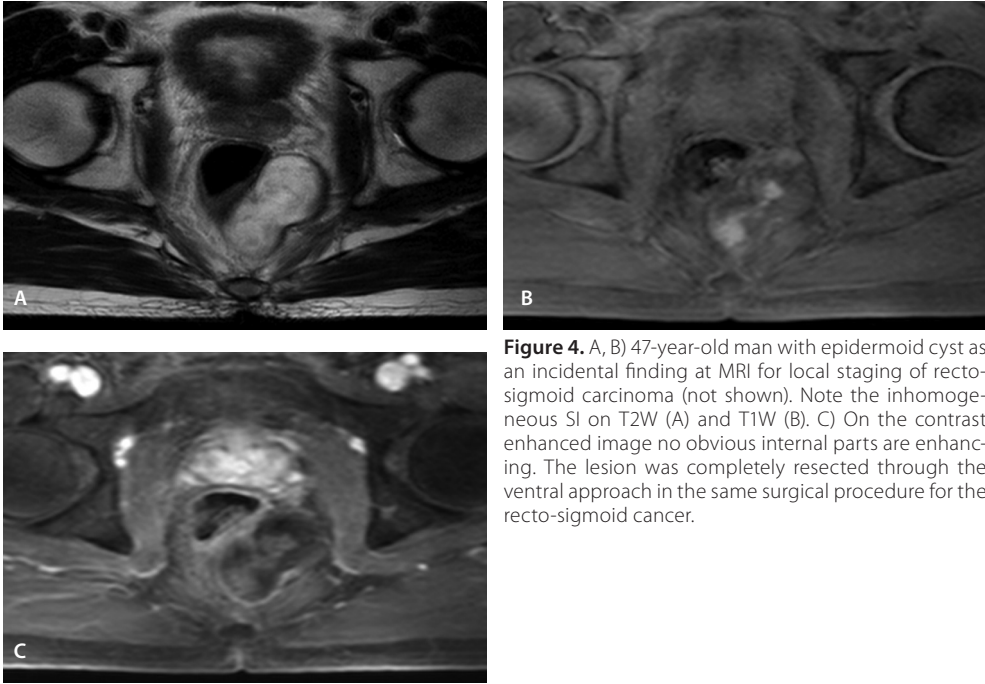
A, B) 47-year-old man with epidermoid cyst as an incidental finding at MRI for local staging of recto-sigmoid carcinoma (not shown). Note the inhomogeneous SI on T2W (A) and T1W (B). C) On the contrast enhanced image no obvious internal parts are enhancing. The lesion was completely resected through the ventral approach in the same surgical procedure for the recto-sigmoid cancer.
